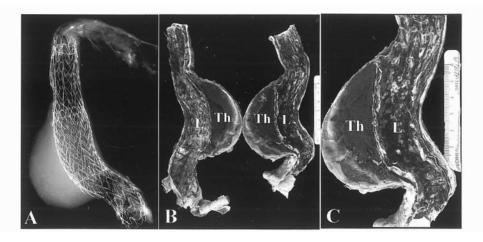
A postmortem radiograph of a thoracic aortic aneurysm treated with two percutaneously placed thoracic excluder stent grafts (A). Shortly after the procedure, the patient suffered two strokes and died on the sixth hospital day from respiratory failure. B and C are gross photographs of the aortic stent grafts cut longitudinally. Note the thrombus (Th) within the body of the aneurysm is totally excluded from the stent graft lumen (L).
